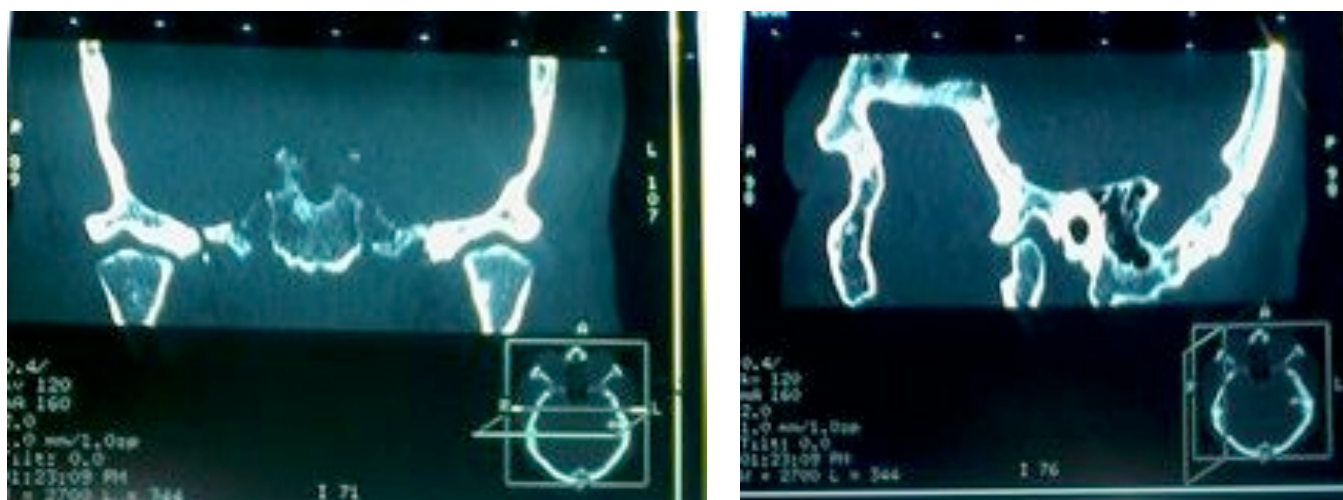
Coronal CT of the Right TMJ of patient p.4 showing slight increase in the superior joint space laterally B. Sagittal CT of the same patient to demonstrate the slight increase in the superior joint space.
